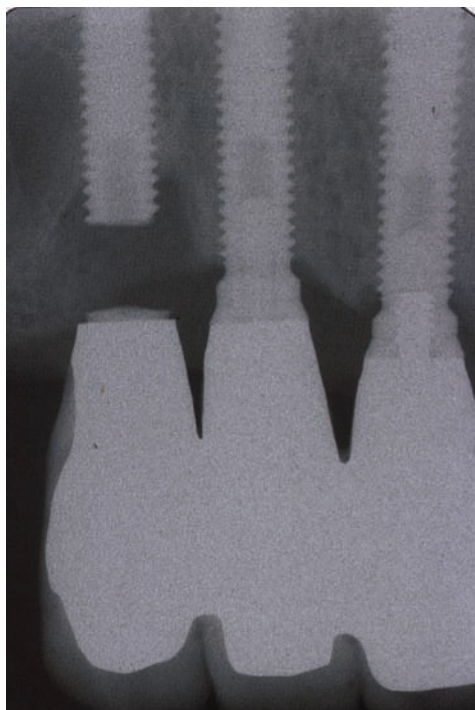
A radiograph of three Branemark implants supporting a maxillary bridge that had been subjected to excessive loading. The patient was a bruxist. The anterior implant (*right*) had previously suffered a fractured abutment screw, the top half of which was removed and replaced with a gold screw (more radiopaque) but the apical part could not be removed. The distal implant (*left*) had a similar history that was subsequently followed by fracture of the implant at the level of the apex of the abutment screw. The latter situation usually requires removal or burial of the fractured implant.
